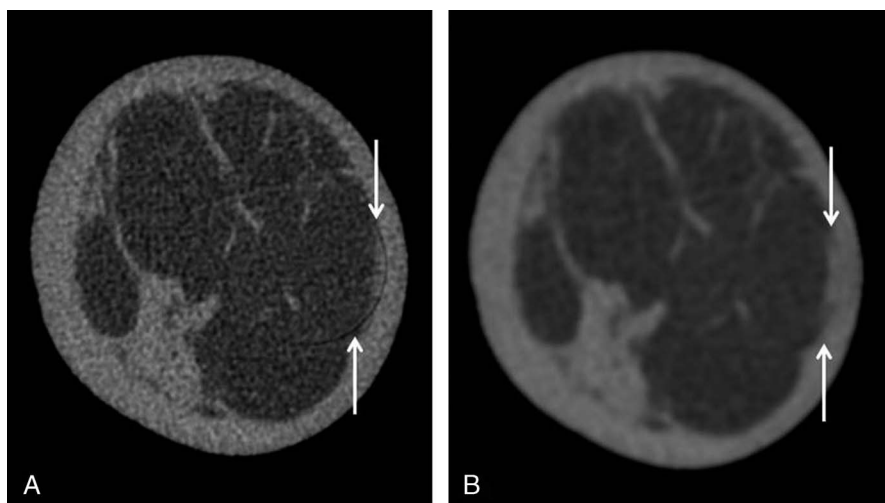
Ring artifact in a B-CT image. The artifact is more prominent on HR (A) as opposed to ST (B), however, did not impair image evaluation.
